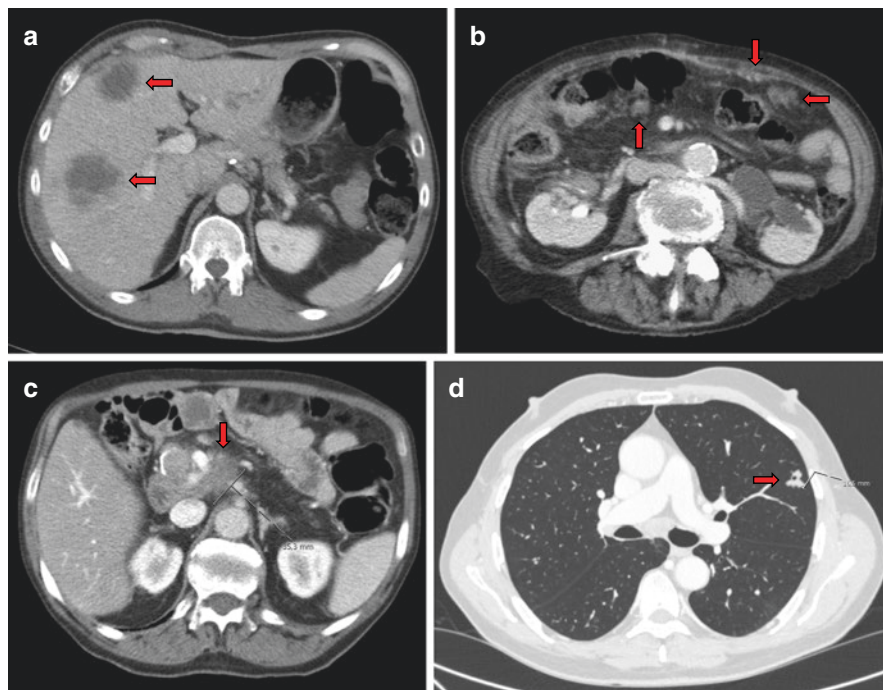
Transversal CT imaging of different patients showing various pancreatic cancer recurrence locations. (a) hepatic recurrence, (b) peritoneal carcinomatosis, (c) local recurrence, and (d) pulmonary recurrence
